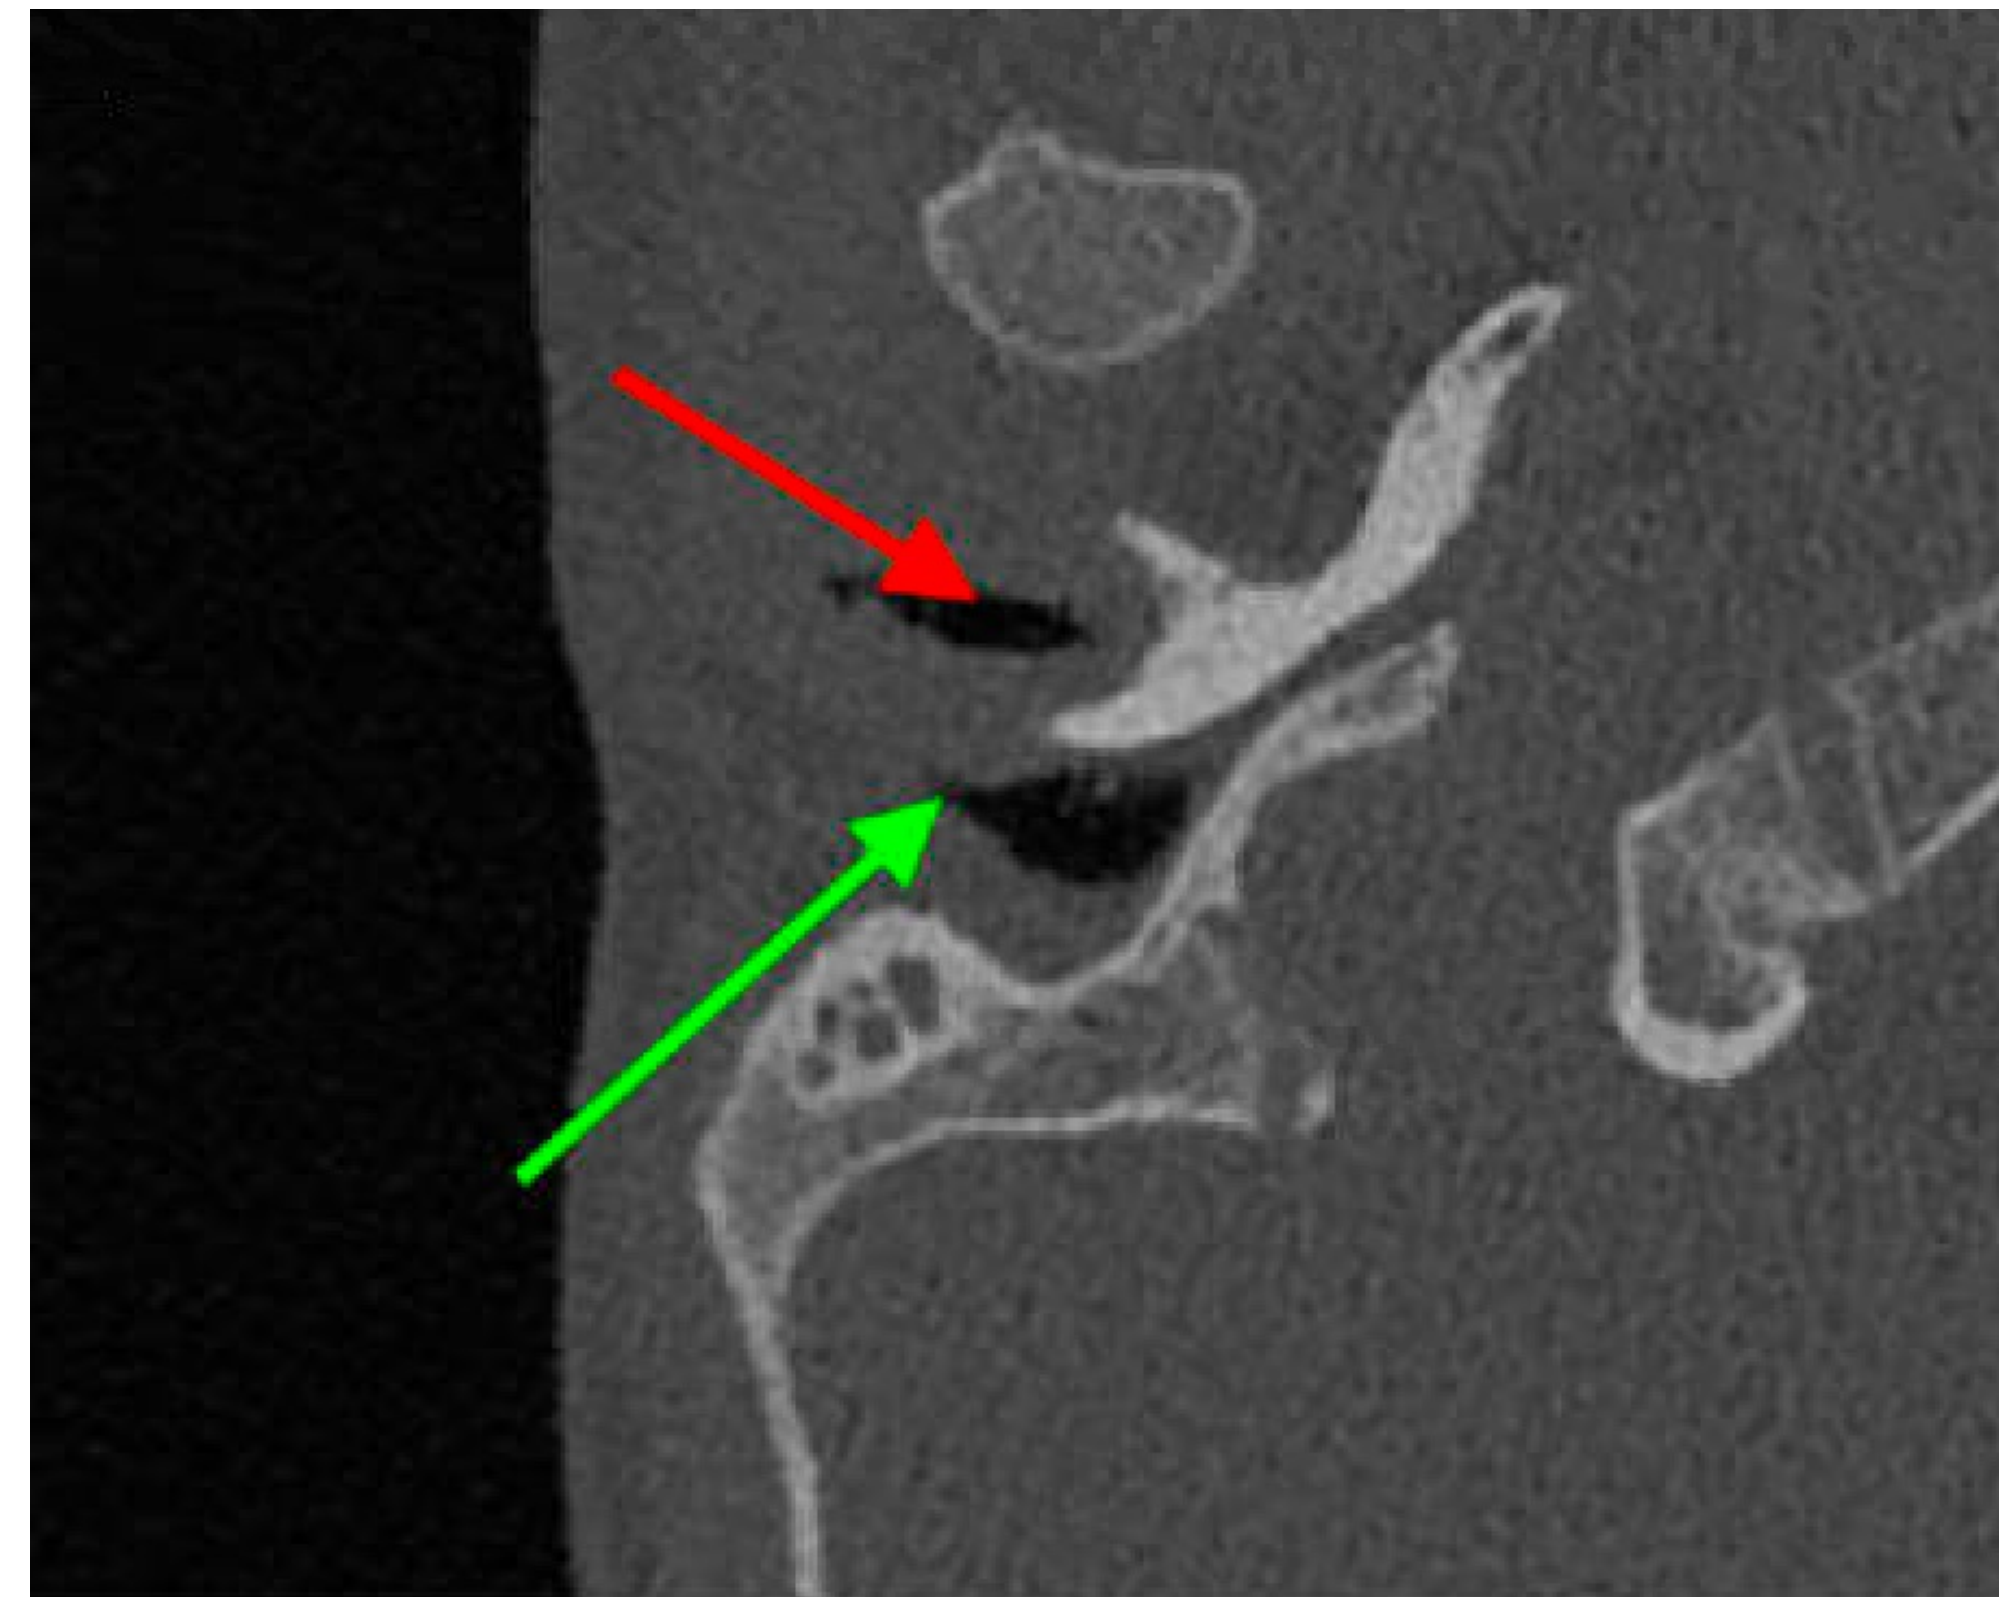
Computed tomography of the temporal bone on axial view demonstrating retroauricular fistula tract from the mastoid cavity to the post-auricular skin (green arrow) adjacent to the normal external auditory canal (red arrow).
